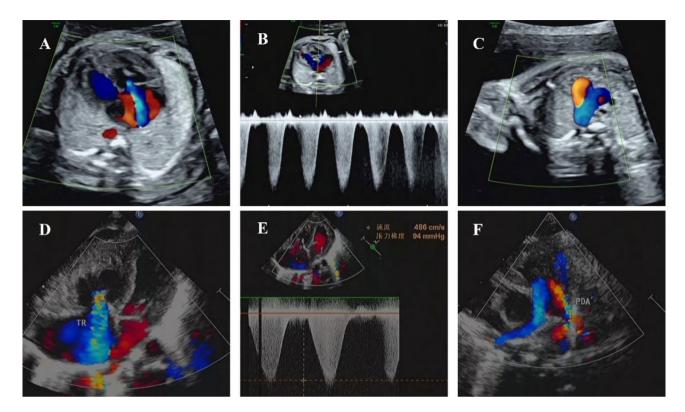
Prenatal and postnatal imaging findings of PA/IVS. (A) Prenatal ultrasound demonstrating severe regurgitation (large regurgitant jet); (B) Spectral doppler showing peak regurgitant velocity (416 cm/s). (C) Retrograde ductus arteriosus (DA) flow into pulmonary artery. (D-F). Postnatal echocardiography confirming prenatal findings with consistent anatomical and hemodynamic features
